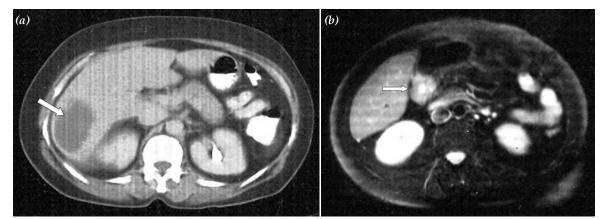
(a) Computed tomography of the abdomen demonstrated a round, 8x11x12 cm diameter collection of fluid and air in the undersurface of the right hepatic lobe (arrow). (b) Computed tomography demonstrates a 3x3 cm diameter lesion (arrow) adjacent to the duodenum.
